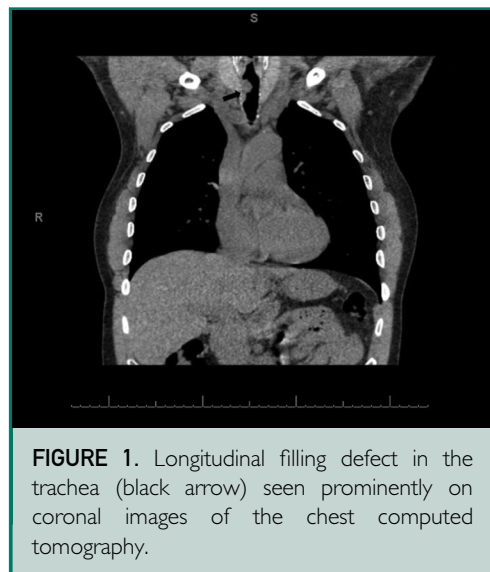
Longitudinal filling defect in the trachea (black arrow) seen prominently on coronal images of the chest computed tomography.
